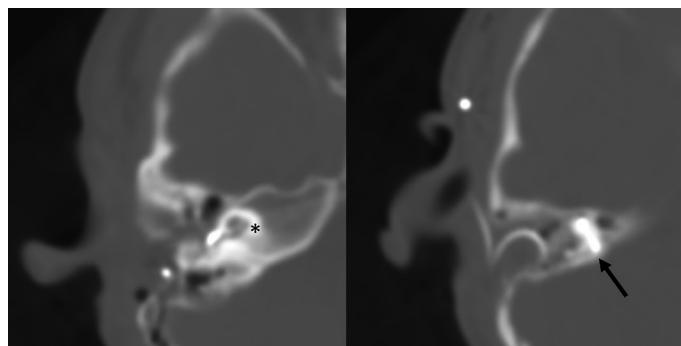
Cochlear implant electrode in superior semicircular canal (black arrow) in axial CT (asterix: cochlea).
